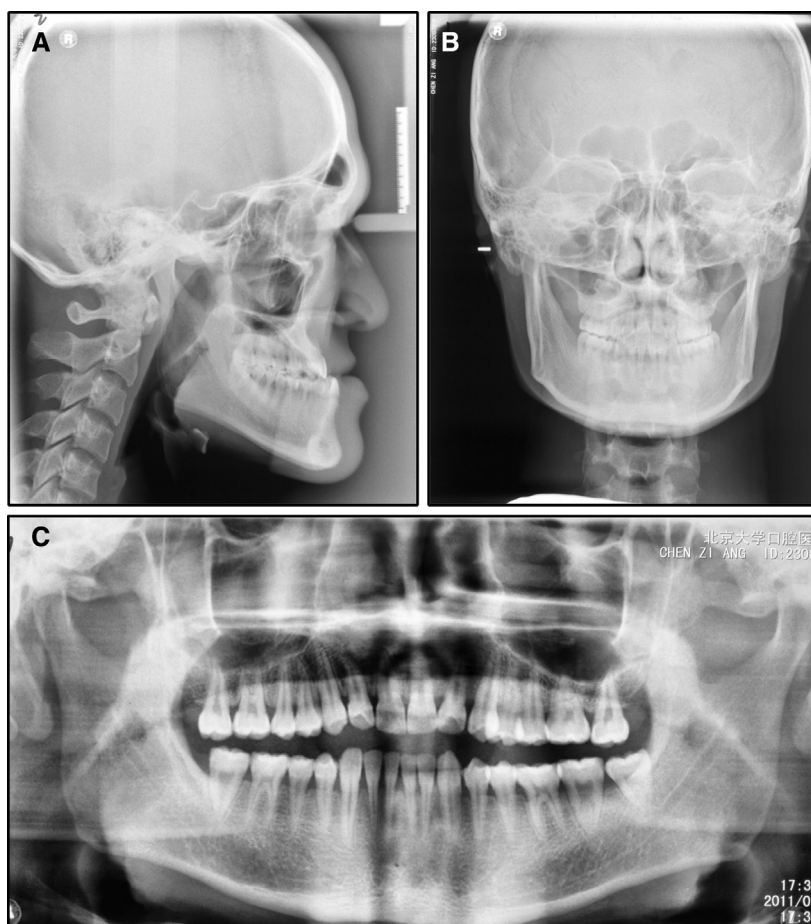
Pretreatment radiographs: A, lateral cephalogram; B, posteroanterior radiograph; C, panoramic radiograph.
